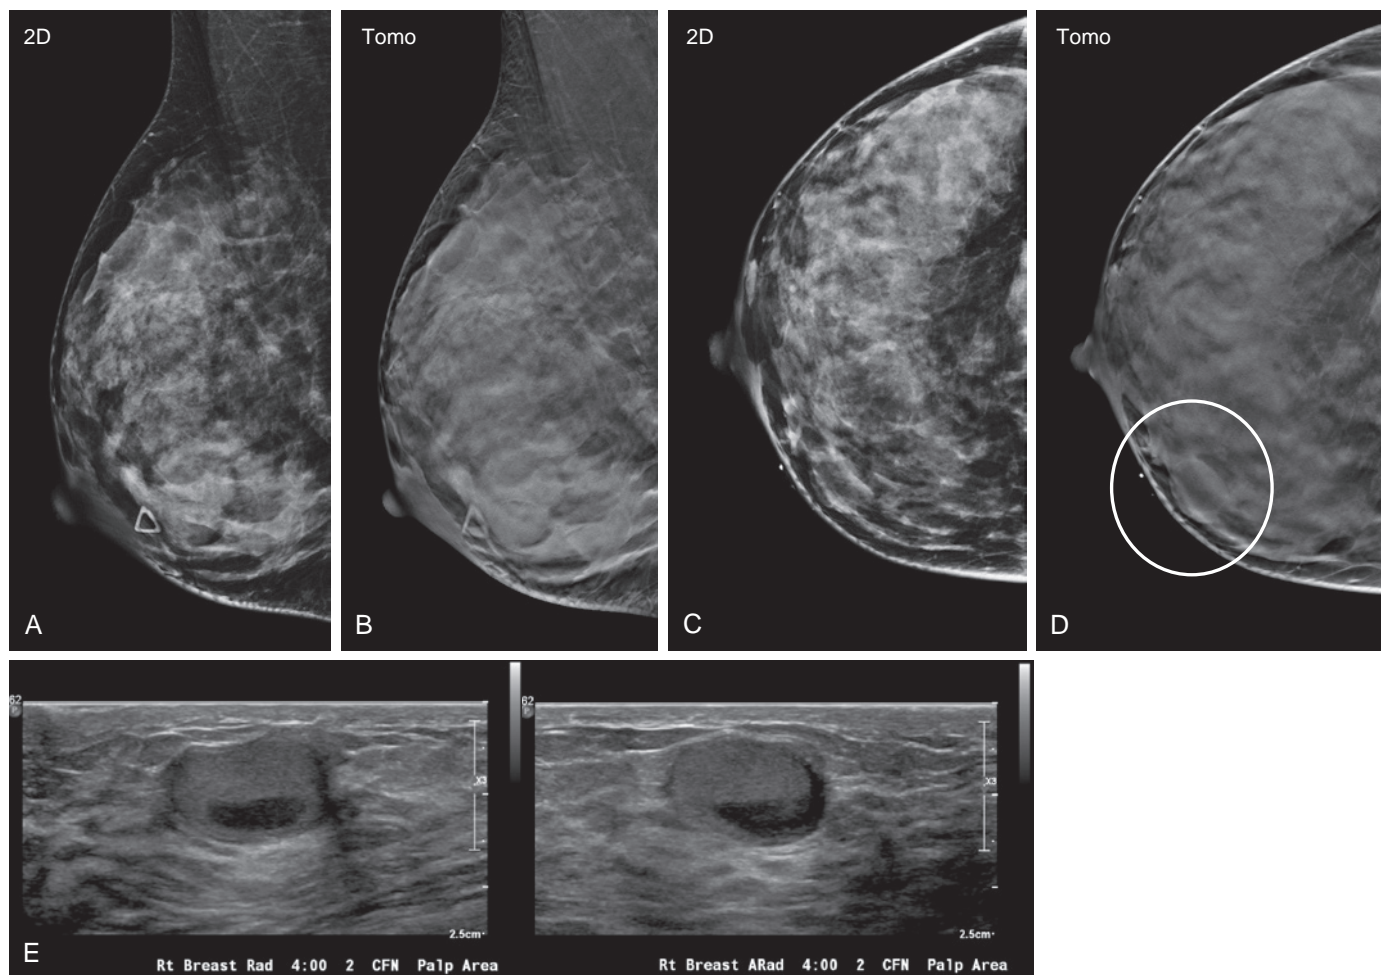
Galactocele. A 37-year-old woman, 3 months postpartum and recently breast-feeding, presents with a palpable lump in her right breast. Mediolateral oblique views in two-dimensional (2D) imaging (A) and tomosynthesis (B) and craniocaudal views in 2D imaging (C) and tomosynthesis (D) demonstrate extremely dense breast tissue. A mass is seen in the right breast at the 4-o'clock position, corresponding to the area of palpable concern. Tomosynthesis images more clearly demonstrate lucency within the mass (*circle*). (E) Ultrasound demonstrates a fat-fluid level within the mass, compatible with a galactocele. The patient opted for ultrasound-guided aspiration, which yielded milky fluid and complete resolution of the mass.
